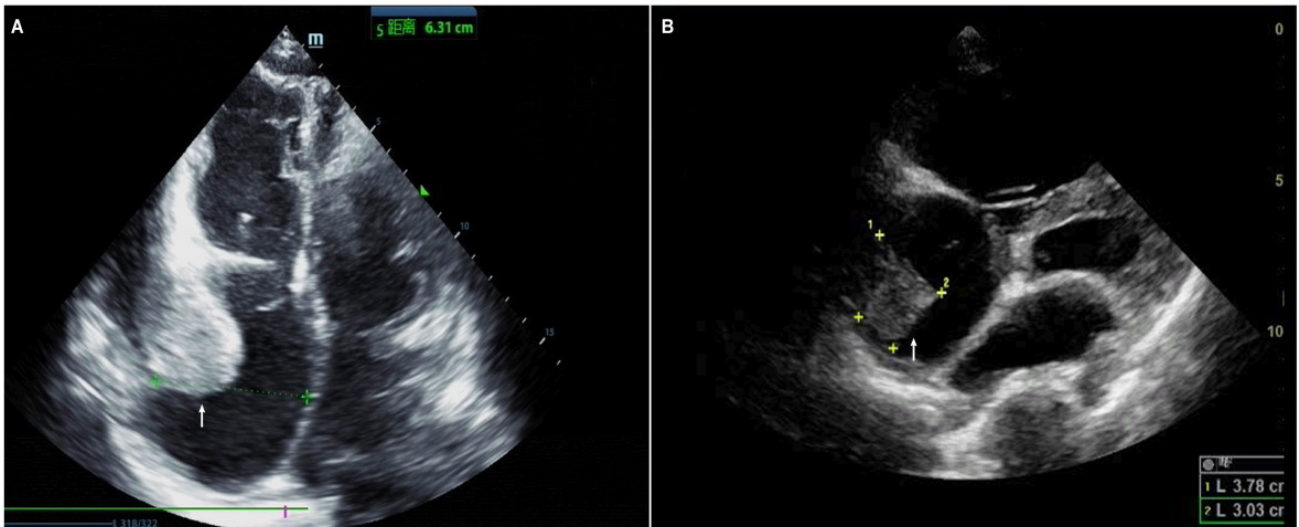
An echocardiogram showed a right atrium thrombus. (A) Apical four-chamber view. (B) Subxiphoid four-chamber view. The white arrows in the Fig. 2A and B indicates a right atrial thrombus.
